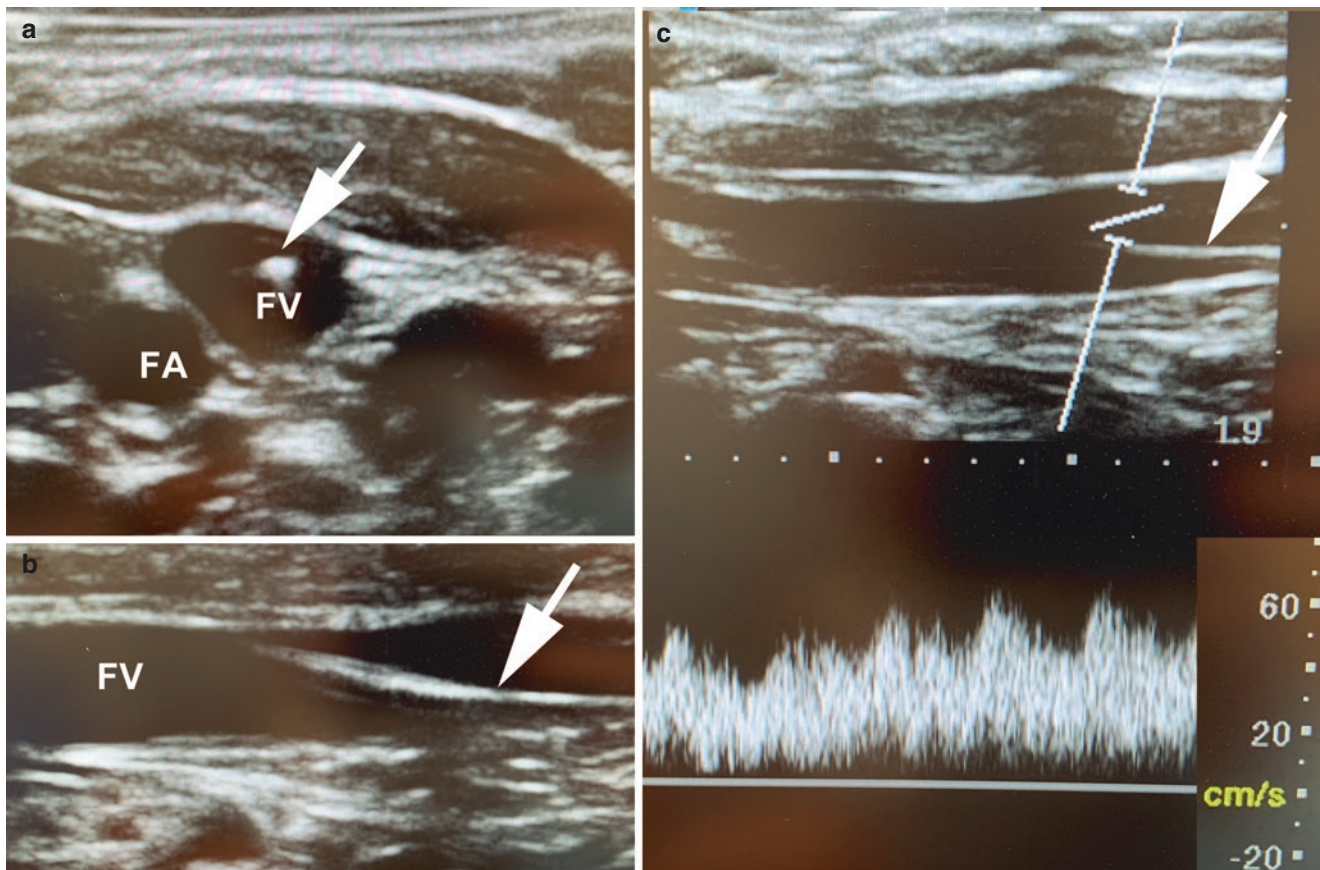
Panel a, short-axis image obtained during ultrasound-guided right femoral venous (FV) access depicting the location of a catheter within the vein (arrow). Panel b, corresponding long-axis view
